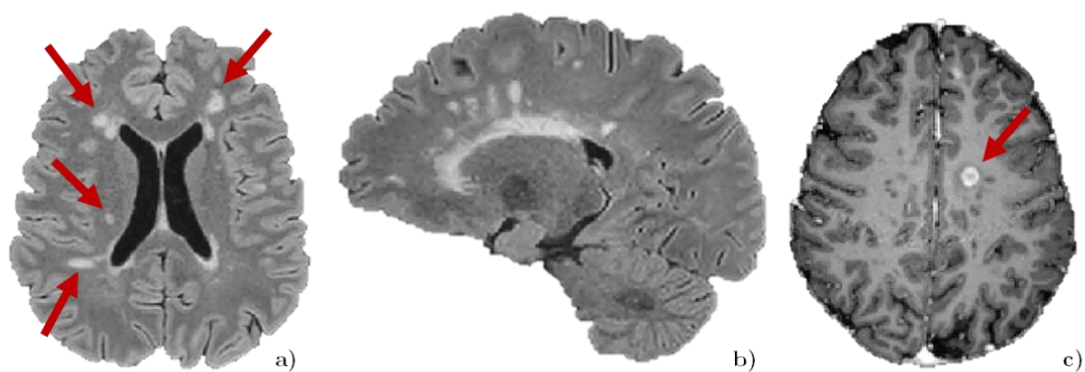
WM lesions in different MR images.
